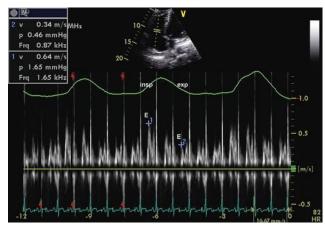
Cardiac tamponade: PW Doppler recording of tricuspid inflow assessing respiratory variation in a patient with cardiac tamponade. As in Figure A5, the respirometer denotes inspiration (insp) and expiration (exp). The peak E waves in inspiration (1=64 cm/sec) and exp (2=34 cm/sec) are noted. Respiratory variation from expiration is calculated by the formula (expiration — inspiration)/expiration or, in this example, (34-64)/34=-87%. Generally, >60% tricuspid inflow variation is expected in presence of cardiac tamponade.
